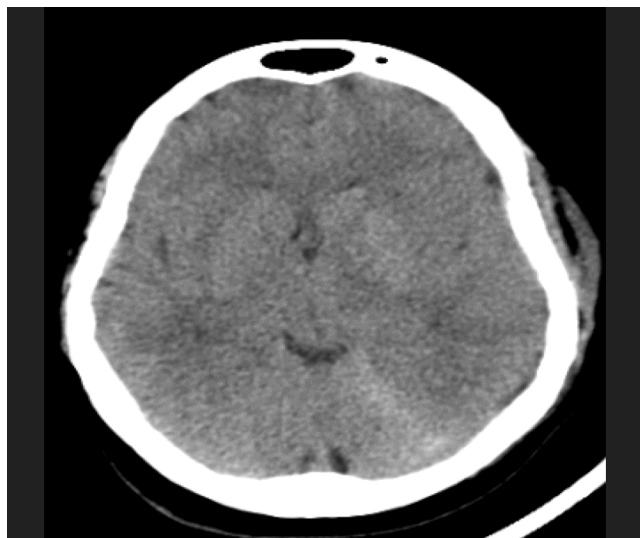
Post-operative brains CT after subdural hematoma drainage.
